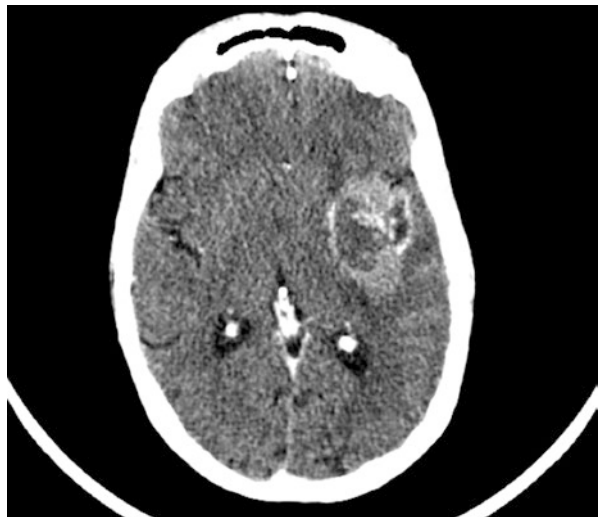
CT with contrast of left peri-sylvian glioblastoma
